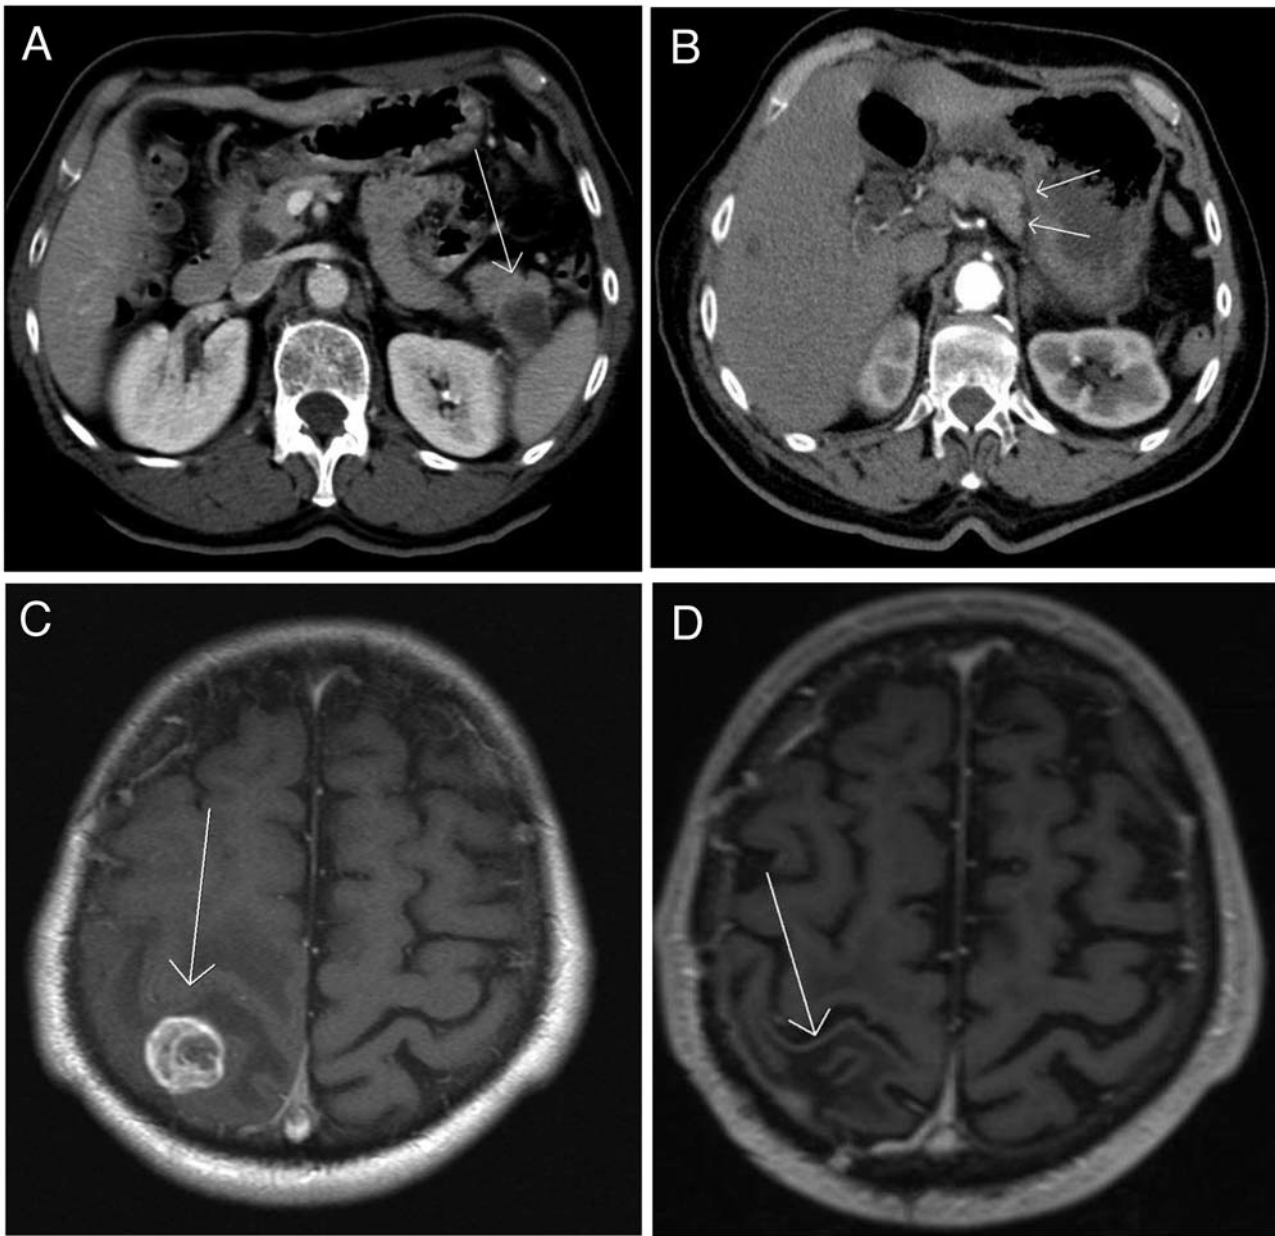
Imaging identifying the primary tumor and the brain metastasis, as well as recent follow-up imaging of abdomen and brain (Case 2). A: Computed tomography of the abdomen in July 2004 revealed a tumor of the pancreatic tail (white arrow) that was diagnosed as pancreatic ductal adenocarcinoma (PDAC) (UICC Stage IIb; pT3, pN1, M0, G2, R0). B: Computed tomography of the abdomen (April 2011) performed as follow-up after resection of the PDAC showed the resection margin of the pancreatic corpus (white arrows) with no evidence of tumor recurrence. C: Magnetic resonance tomography of the brain (June 2005) revealed a tumor of the right postcentral cerebrum (white arrow) that was identified as a metachronous metastasis of the PDAC. D: Recent magnetic resonance tomography of the brain (March 2011) showed postoperative alterations of the right cerebrum (white arrow) but no evidence of tumor recurrence.
